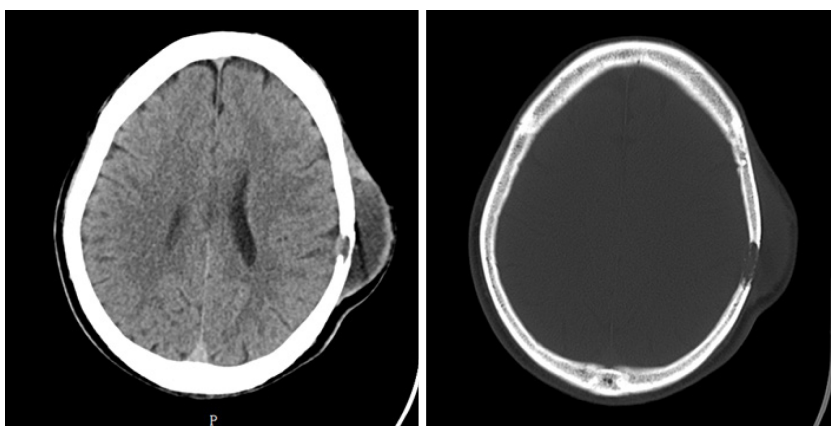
Computed tomography shows a soft tissue mass in the left temporal region and destruction of the adjacent skull.
